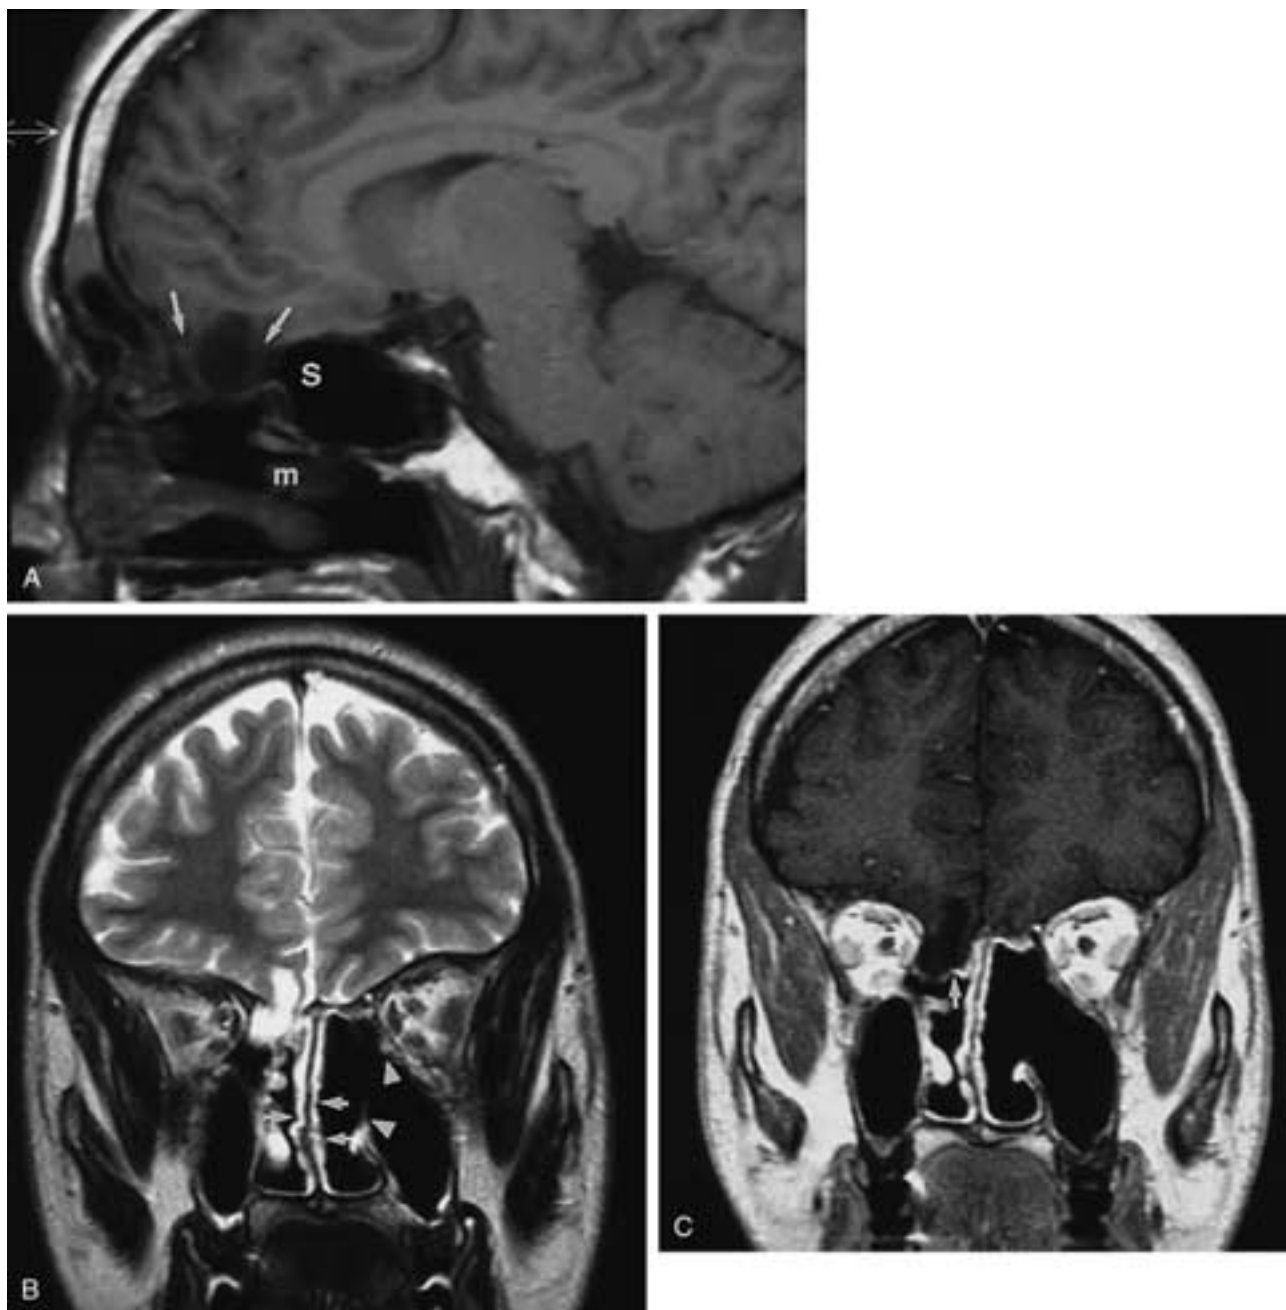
Pseudomeningocele, right. Persistent “sinusitis” with nasal discharge was noted 1 year following FESS. A, T1-weighted sagittal MR image shows a large anterior skull base defect in the posterior ethmoid complex (*arrows*), immediately anterior to the sphenoid sinus (*S*), with intranasal herniation of meninges and CSF. Note that the midportion of the middle turbinate has been resected. The residual posterior middle turbinate is denoted by *m*. B, On the T2-weighted coronal MR image, the right intranasal pseudomeningocele is noted, and is clearly contiguous with a region of encephalomalacia in the anterior frontal lobe. Postoperative changes include an irregular septal contour following a septoplasty (*arrows*), total left ethmoidectomy, marked widening of the left maxillary ostium and infundibulum (*arrowheads*), and complete resection of the left middle turbinate, including the vertical insertion. C, T1-weighted coronal contrast-enhanced MR images show subtle enhancement of the inferior aspect of the pseudomeningocele (*arrow*) and normal mucosal enhancement of the nasal cavity.
